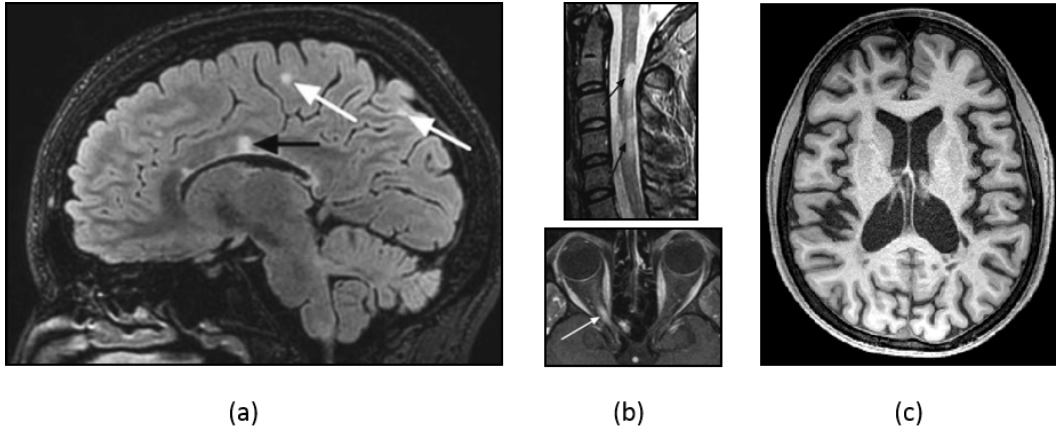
Lesions characteristic of MS. (a) Sagittal image with WM lesions (black arrow) and juxtacortical lesions (white arrows) on T2-weighted FLAIR; (b) Other common lesion locations in MS include spinal cord (top image, black arrows, sagittal T2-weighted sequence) and optic nerve lesions (bottom image, white arrows, gadolinium-enhanced T1-weighted MRI); (c) Brain atrophy typically manifests through brain parenchymal shrinkage and is usually quantified in T1-weighted MRI (images taken from [37] and from MS Rehab study, University Hospital of Basel).
